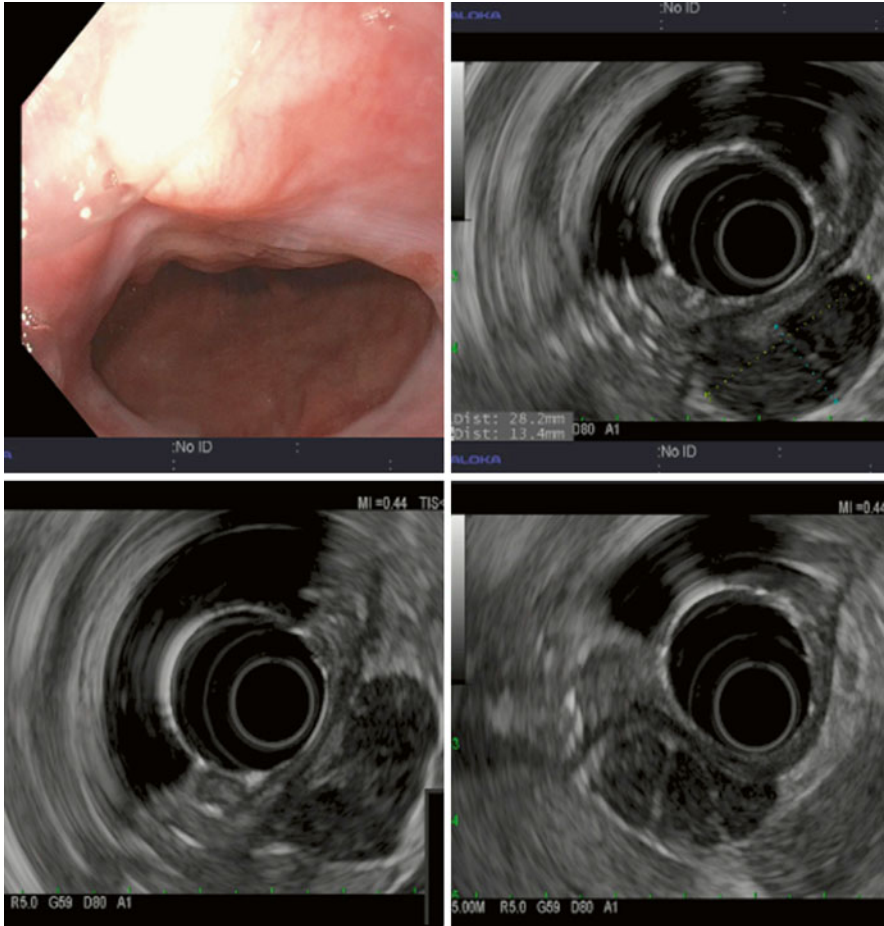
Endoscopy with endoscopic ultrasound. Esophageal leiomyoma
